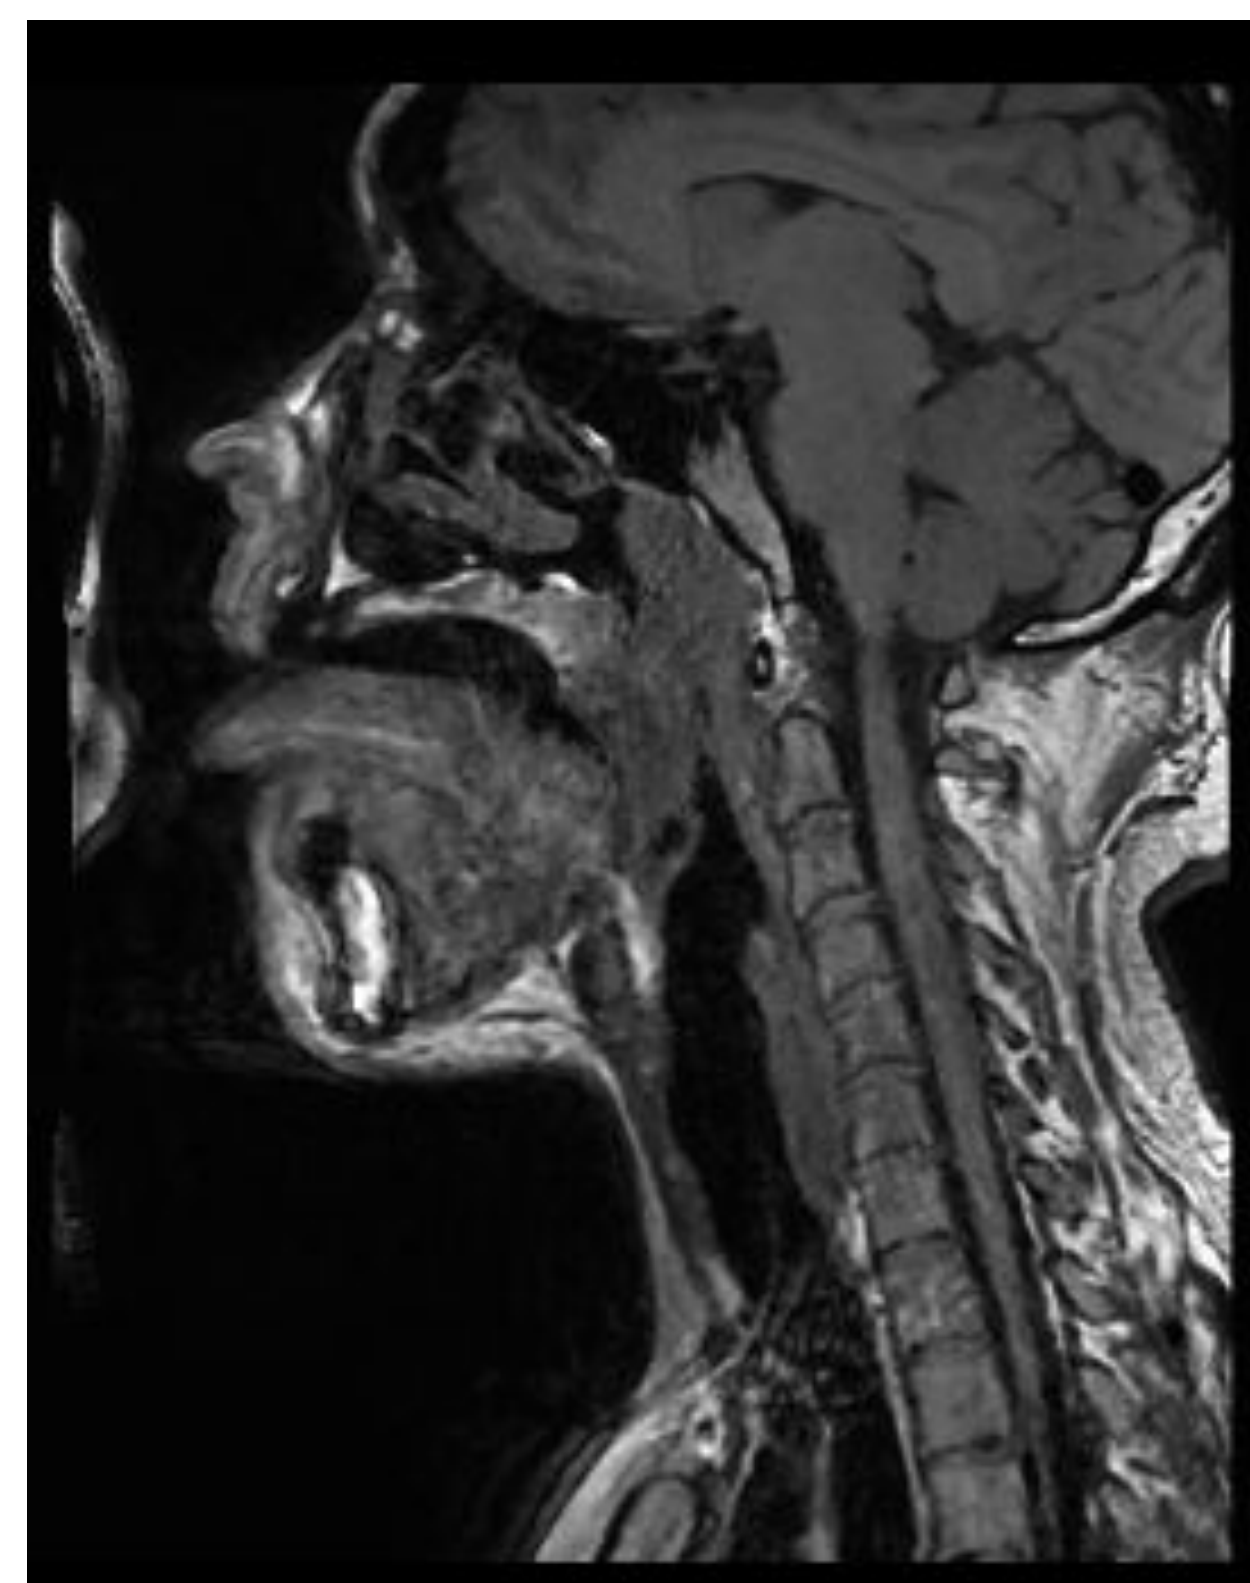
Volunteer Airway MRI
